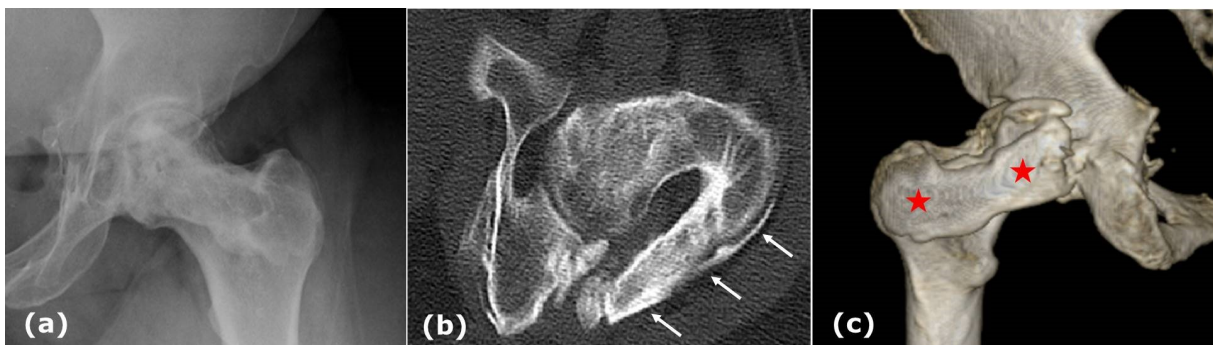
(a) Patient's left Hip AP radiograph suggesting a vague rectangular ossified mass traversing the left neck of femur with reduction of superior hip joint space, (b) computed tomogram scan showed a well-defined, mature trabeculated ossified mass extending from the greater trochanter to the posterior column of the left acetabulum (White arrows) and (c) which measured approximately 8 cm in length (red stars). [Click on image].
